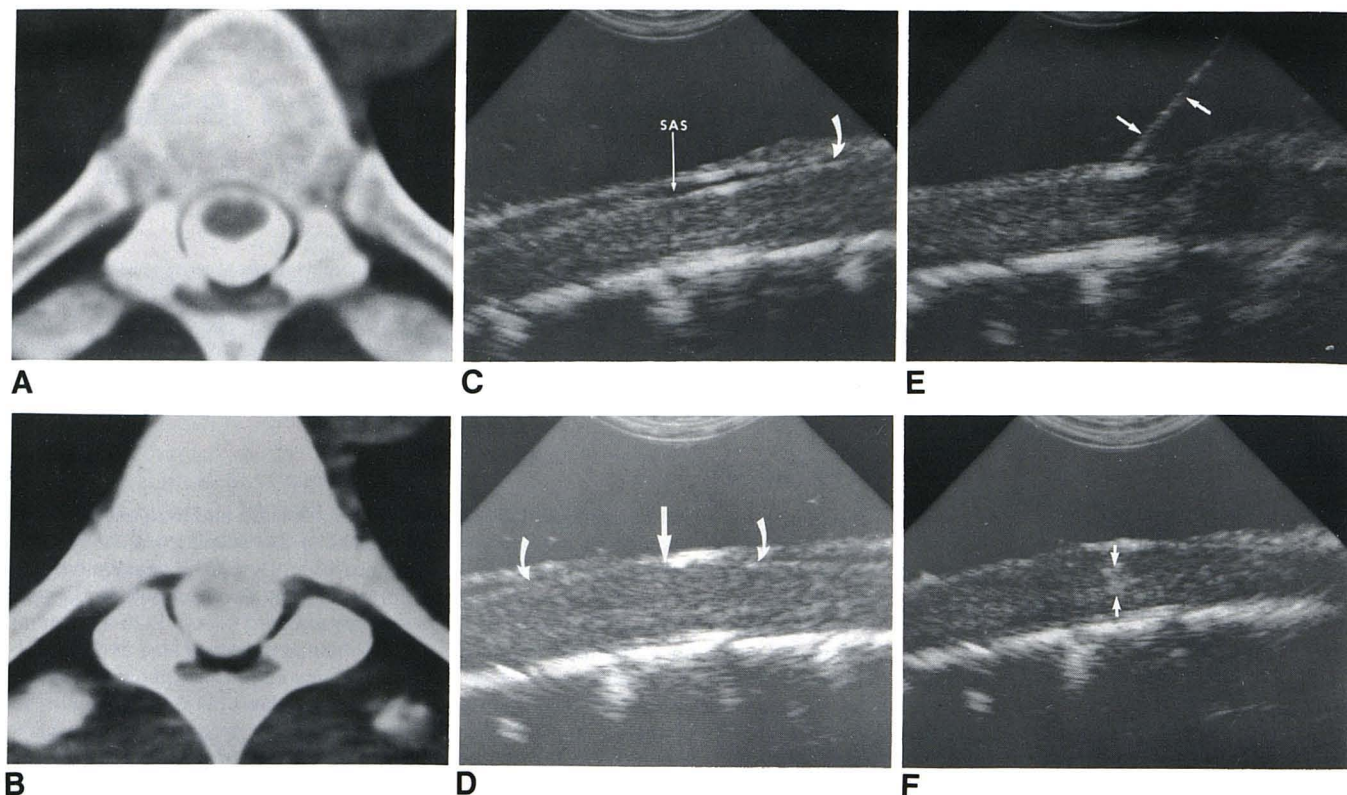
Progressive spastic paraparesis. Myelogram was normal, but, because of high degree of clinical suspicion of thoracic cord mass, immediate and 4 hr delayed water-soluble contrast (metrizamide) CT was performed. A, Immediate metrizamide scan. No evidence of cord enlargement. B, Delayed scan at same level (T5). Diffuse infiltration of metrizamide into cord substance. On the basis of delayed metrizamide CT, a process that had changed the permeability of the spinal cord was suspected, e.g., myelitis, infarction, or tumor. Because of the patient's progressive neurologic deterioration, infiltrating neoplasm was believed most likely, even though there was no radiologic evidence of cord enlargement. Surgery was recommended, and a T4–T5 laminectomy was performed. C, Initial IOSS. Normal subarachnoid space (SAS) and normal-sized cord in center of field. At caudal end of operative site, cord began to enlarge and subarachnoid space narrowed (*arrow*). Laminectomy was
